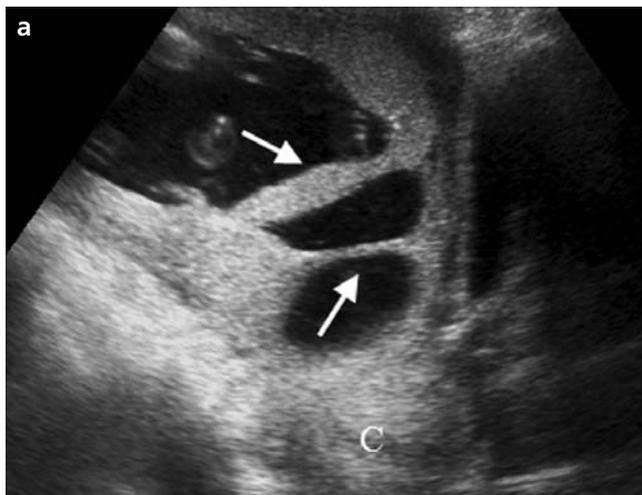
a, b. A sagittal gray-scale US view (a) of the patient no. 5 showing the double amniotic sheets (arrows), located close to one another (C, cervix). A color Doppler US and spectral analysis (b) of the thicker amniotic sheet revealed a low-resistance arterial flow and a heart rate of maternal origin.
